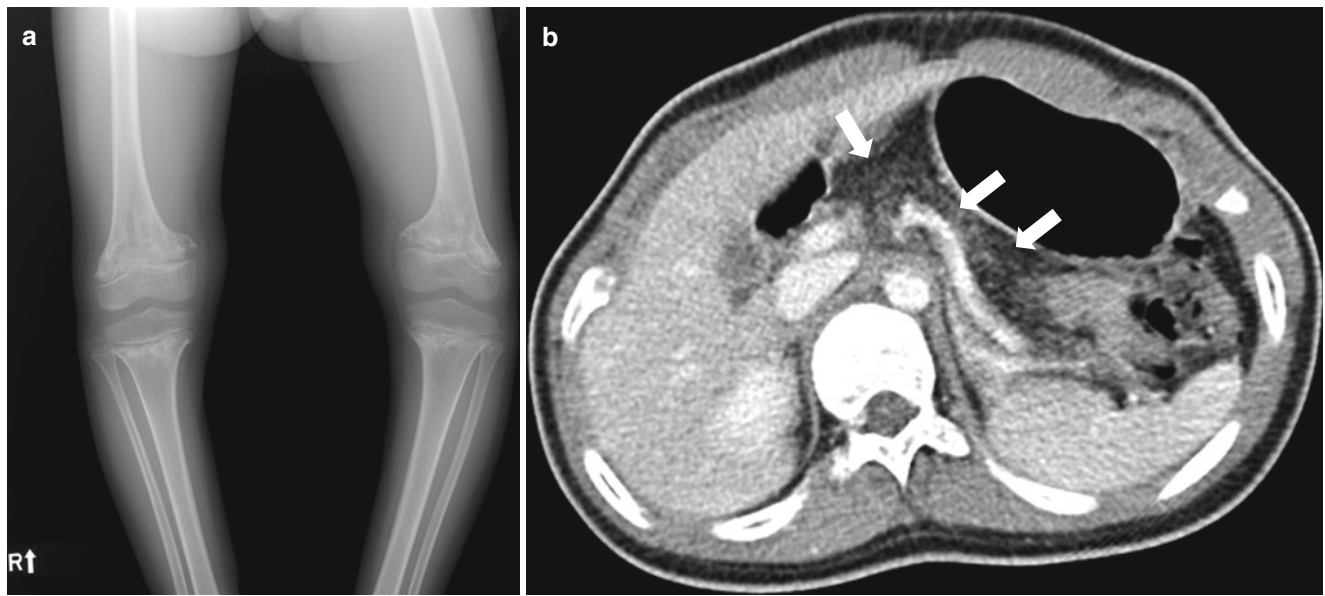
Shwachman-Diamond syndrome.* (a) Metaphyseal ossification is markedly irregular with splaying and fraying of the metaphyses. (b) Abdomen CT demonstrates pancreatic lipomatosis (arrows)
